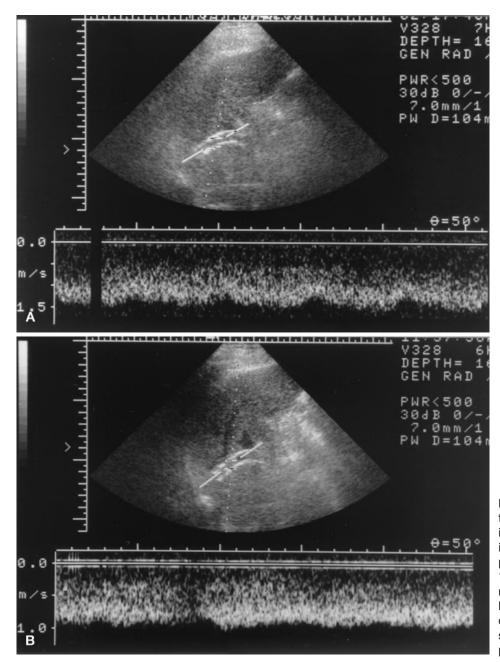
A Doppler spectrum of a normal shunt. Maximal intra-shunt velocity immediately after TIPS placement is approximately 150 cm/sec. B Eighteen months later intra-shunt velocity has decreased to 90 cm/sec. A significant shunt stenosis was detected on portal venography.
